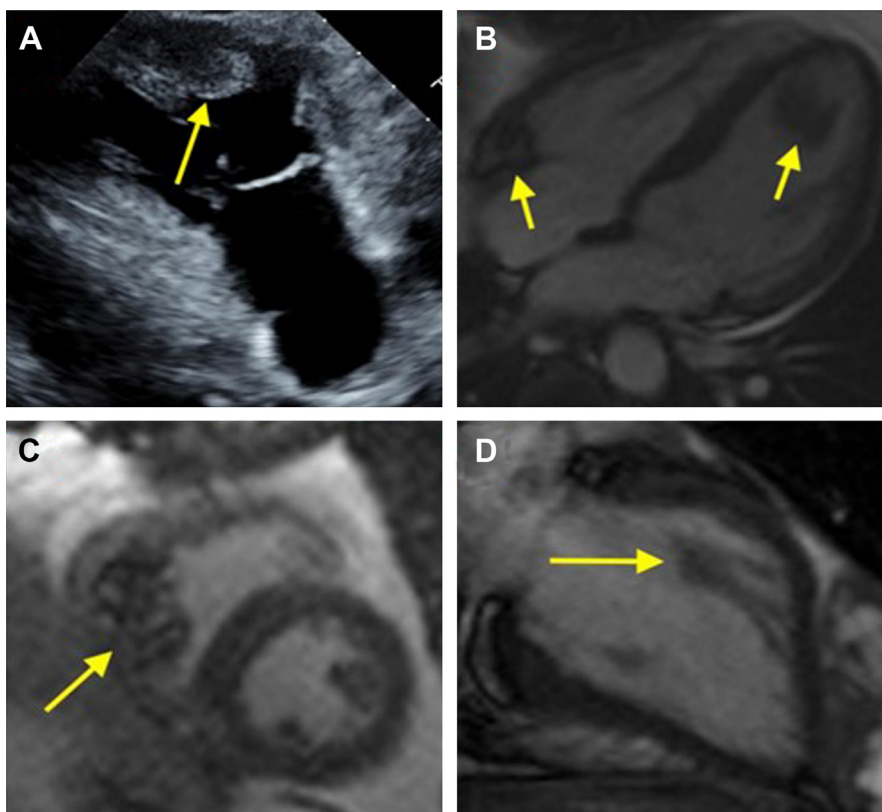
(A) Mass identified in the RV outflow tract on echocardiography. Suspected to be a metastatic lesion from an unknown primary source. (B) Two masses identified on CMR (horizontal long axis view). The LV mass is a metastatic melanoma. The RA mass is a thrombus. (C) One RV mass on CMR (short axis view), diagnosed as metastatic melanoma with surrounding thrombus. (D) One LV mass identified on CMR (vertical long axis view), diagnosed as a poorly differentiated synovial sarcoma.
